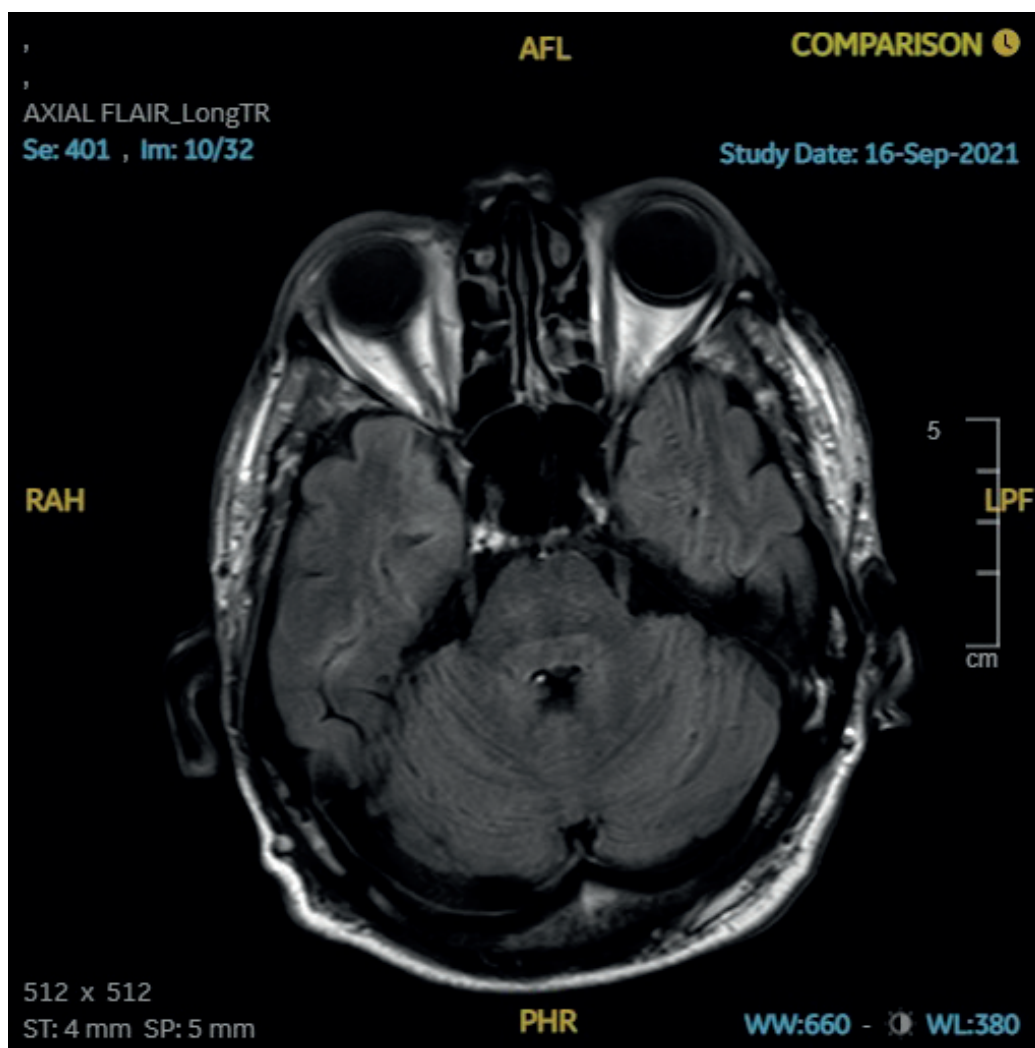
MRI imaging on repeat scanning showed rapid resolution of T2 hyperintensities.
